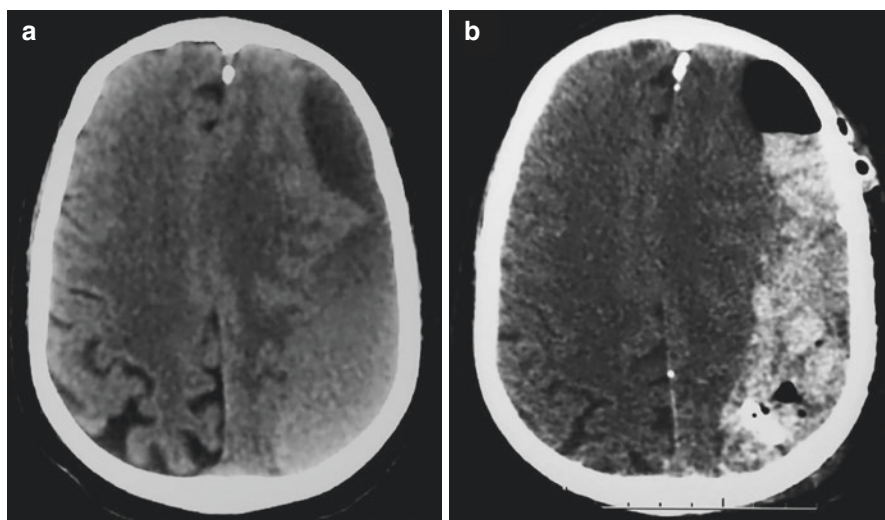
Immediate postoperative subdural bleeding following burr holes evacuation of a chronic SDH. Preoperative (a) and urgent postoperative CT scan (b)
